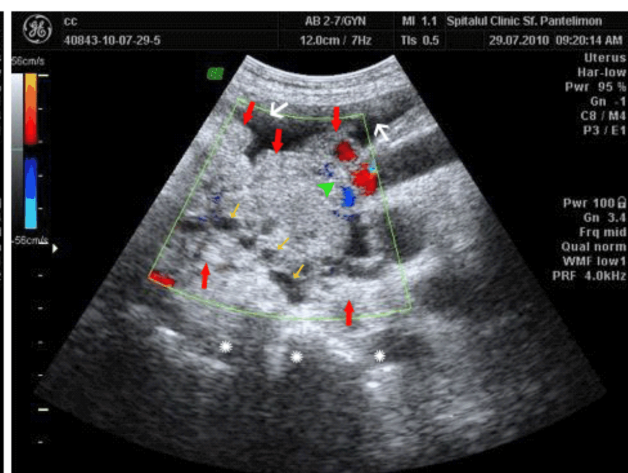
Sagittal sonogram demonstrating heterogeneous moderately echogenic mass (red arrows), pseudocystic spaces (yellow arrows), myometrial invasion (white stars), large areas of hemorrhage (white arrows), strong color Doppler signal (green arrow).
